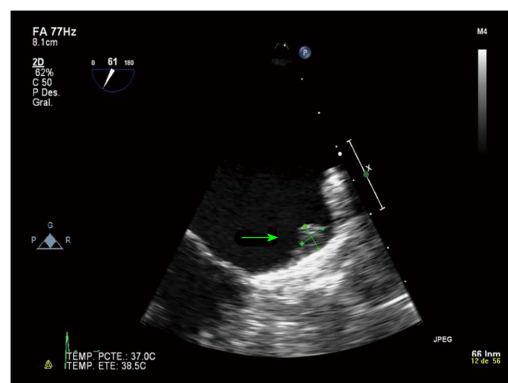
Four month control. Transesophageal echocardiography two-dimensional image. Adequate covering of the left atrial appendage ostium but little thrombus (7 mm × 7 mm) is observed at the top of the button of the Amplatzer™ cardiac plug.
